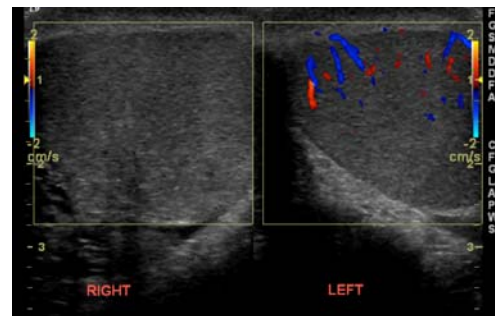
Color Doppler US scan showing blood flow to the left testicle but no blood flow to the right one.
